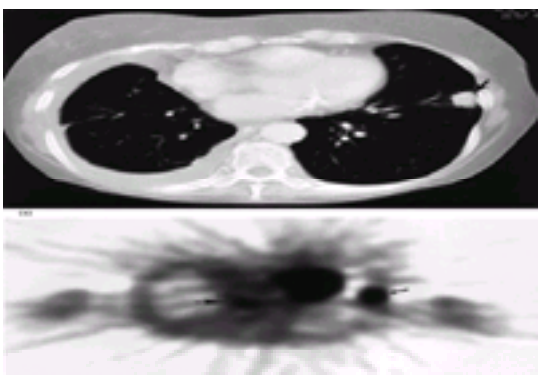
(a) CT scan of a female patient showing a spiculated mass in the left lung (arrow). The pleural effusion did not show malignant cells and mediastinal lymph nodes were indeterminate. (b) FDG-PET showed focal area of increased FDG uptake in the left lung mass and mediastinal uptake on the right side (small arrow), suggesting lymph-node involvement (large arrow).
